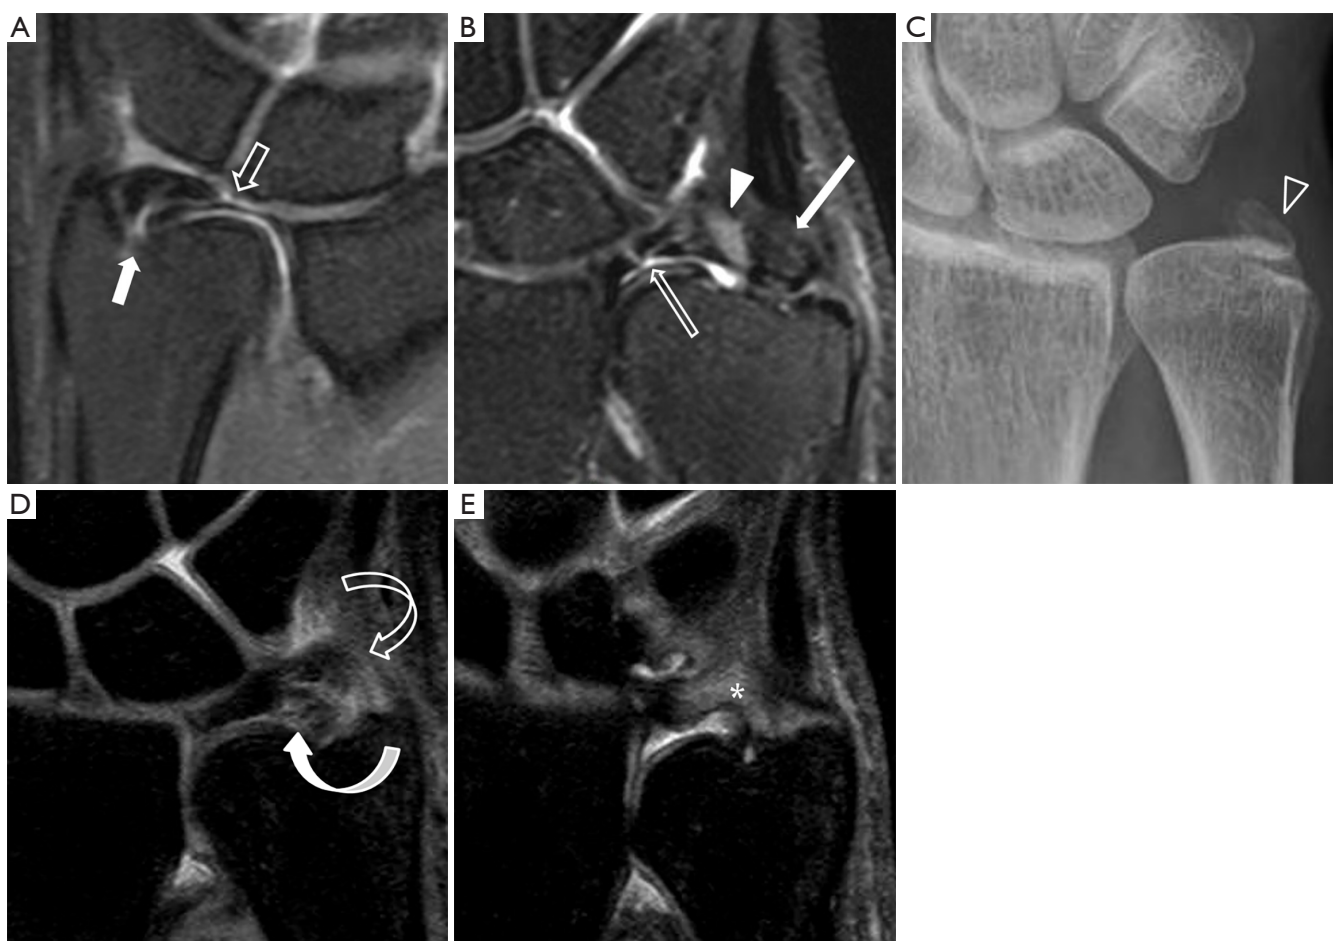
Atypical TFCC tear. (A) Coronal proton density fat-suppressed MR image shows atypical tear of the TFC centrally located and extending from the distal surface (block arrow) to the foveal attachment (solid arrow). This is due to a combination of Palmer classification type 1A and type 1B tears; (B) coronal proton-density fat suppressed MR image shows chronic avulsion fracture at the base of distal ulnar styloid process (solid long arrow). Associated with abnormal high signal in the attachment of TFCC (solid arrowhead). Features are compatible with Type 1B tear. There is also a small linear tear at the paracentral portion of the TFC (block long arrow) compatible with type 1A tear; (C) frontal radiograph of the same patient shows the non-united fracture at the base (block arrowhead) of the ulnar styloid process (type 2). Type 2 fracture is usually associated with TFCC disruption and DRUJ instability. About 65% of patients have non-union of ulnar styloid fractures; (D) coronal proton density fat-suppressed MR image in a patient with DRUJ instability clinically showing a severe partial tear of the proximal (curved solid arrow) and distal laminae (block curved arrow) at the styloid and foveal attachments respectively; (E) in the same patient more dorsally, there is a severe sprain of the dorsal radioulnar ligament with thickening and oedema (asterisk). TFCC, triangular fibrocartilage complex; DRUJ, distal radioulnar joint.
